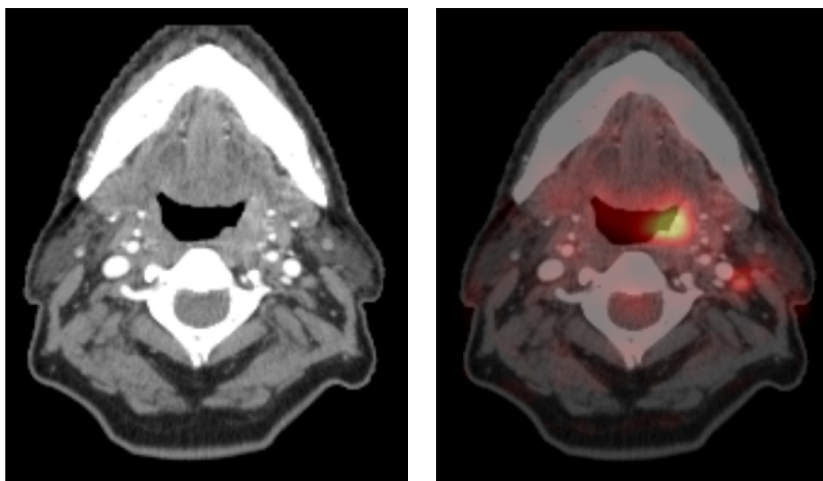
Patient with stage II oropharyngeal carcinoma with a focal uptake in a small lymph node on the left side (level II) on FDG-PET, not diagnosed on CT.
